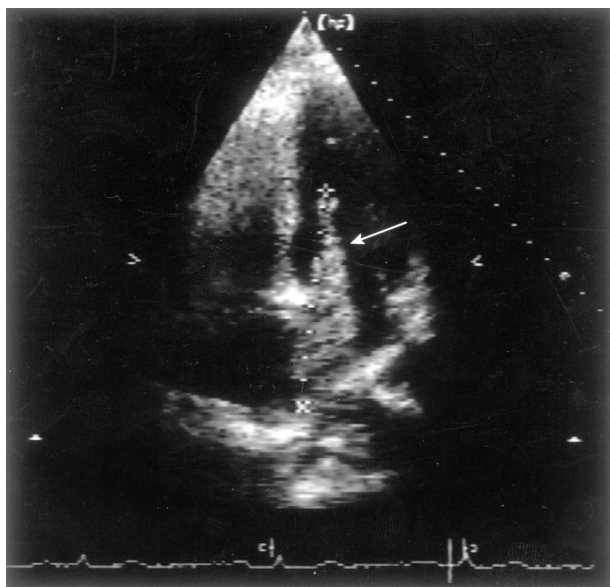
Transthoracic echocardiogram showing 9-cm x 3-cm left atrial myxoma extending from the left atrium into the left ventricle (white arrow).
